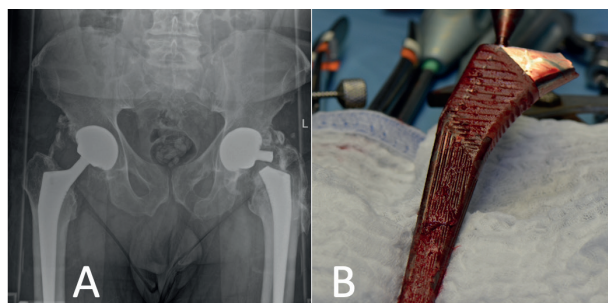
The AP radiograph of the pelvis (Fig 3A) shows implant rupture at the femoral stem neck of the left total hip prosthesis and the presence of extensive heterotopic calcifications. The photograph (Fig 3B) shows the removed stem. The complete fracture in the middle third of the prosthetic neck is visible.
